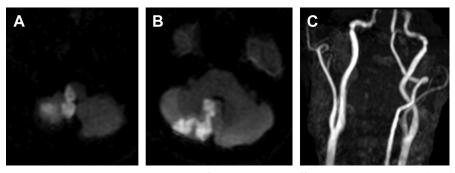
Brain MRI and MR angiography of the case. Axial diffusion-weighted images (*A, B*) show acute infarctions involving the lateral medulla, and infero-medial cerebellum including the nodulus and tonsil on the right side. The right vertebral artery is not visualized on MR angiography (*C*).
